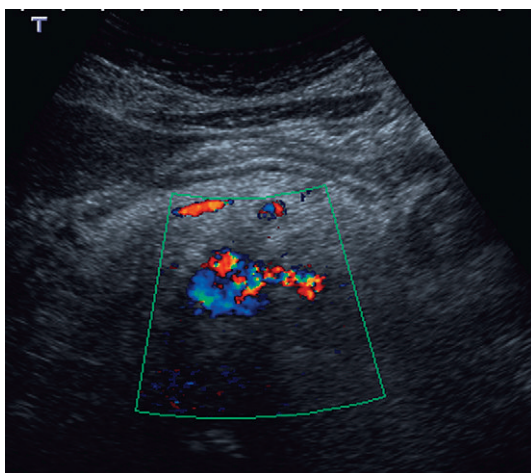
The probe is angled slightly to the left from a position just to the right of the midline demonstrating the origin of the left renal artery in colour flow Doppler.
